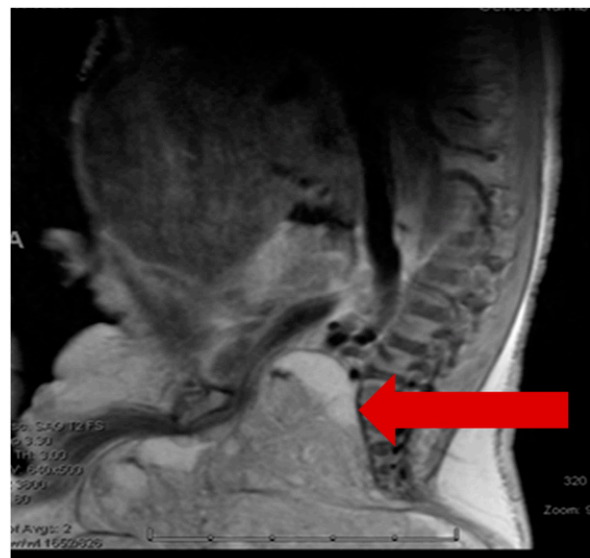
Magnetic resonance imaging scan of the pelvis showed a presacral mass (red arrow) with a large external component and relatively small internal component.
